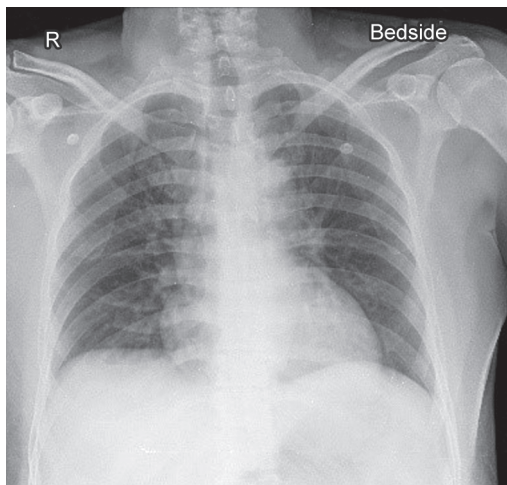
Chest X-ray on postoperative day 7 showing resolution of patchy ground glass opacity
